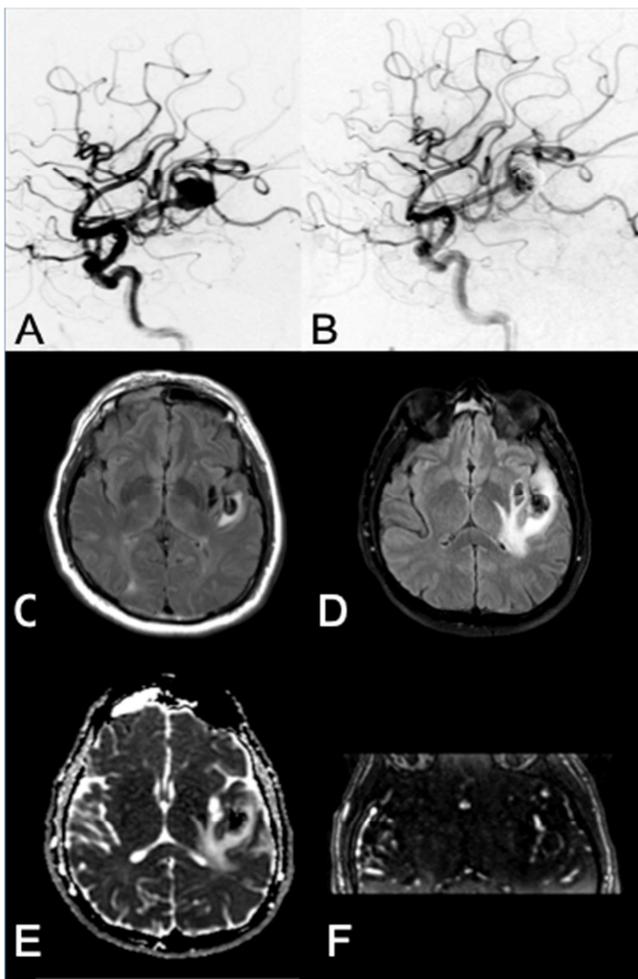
Left M2 aneurysm in contact with parenchyma. Pre-embolization DSA (A), post-embolization DSA (B), FLAIR with parenchymal hyperintensity pre-embolization (C) and post-embolization (D), post-embolization ADC (E), and post-contrast T1 (F).
